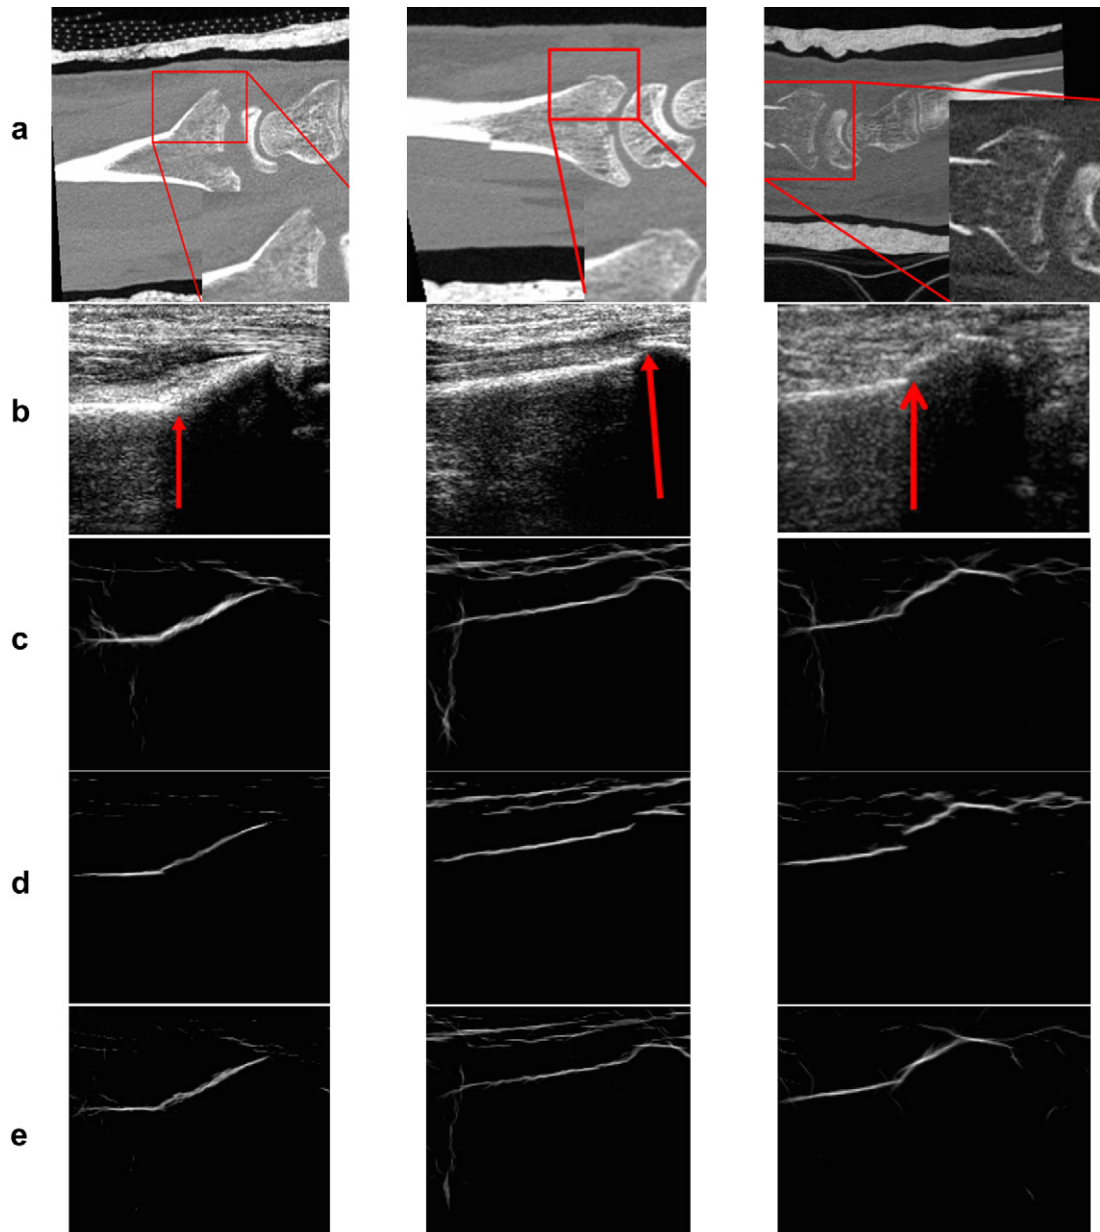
Qualitative results from three clinical studies where the scanned area involved a distal radius fracture: one where the scanned area involved a distal radius fracture. (a) 2-D sagittal CT slice where the zoomed in version shows a clear fracture. (b) B-mode US image red arrow points out to the location of fracture, phase symmetry (PS) image obtained using empirical filter parameters. (c) PS image obtained using the filter parameters obtained from the proposed framework. (d) PS image using filter parameters obtained from exhaustive search procedure. (e) PS image using filter parameters obtained from exhaustive search procedure.
